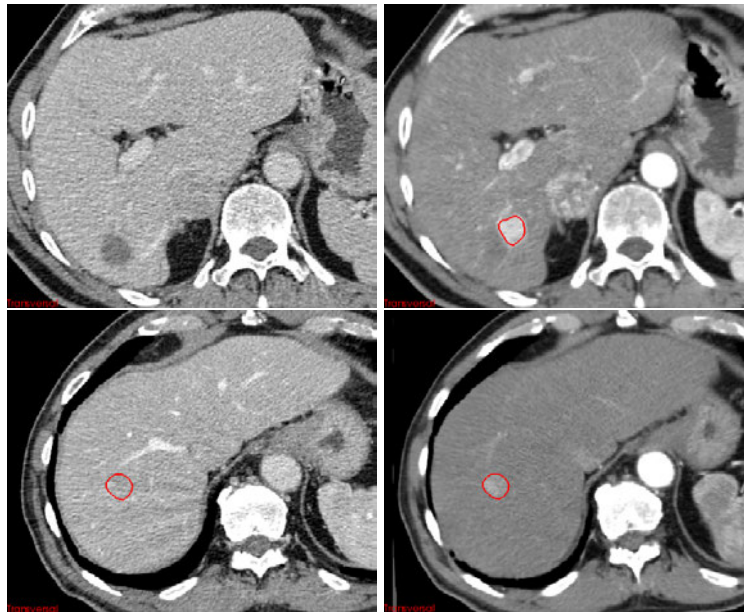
The tumor is only visible in the arterial phase of both CT datasets. Top row: Dataset 1. Bottom row: Dataset 2. Left column: Venous phase. Right column: Arterial phase. Image taken from [DEOLW12].
